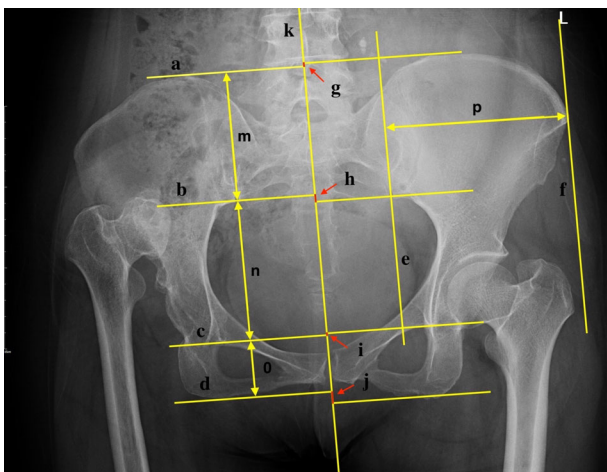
Measurement parameters determined on AP pelvic radiographs: (m) height of ilium area, (n) height of acetabulum area, (o) height of ischium area, (p) width of ilium, (g) the discrepancy of iliac crest, (h) the discrepancy of inferior sacroiliac articulation, (i) the discrepancy of teardrop, (j) the discrepancy of ischial tuberosity.
